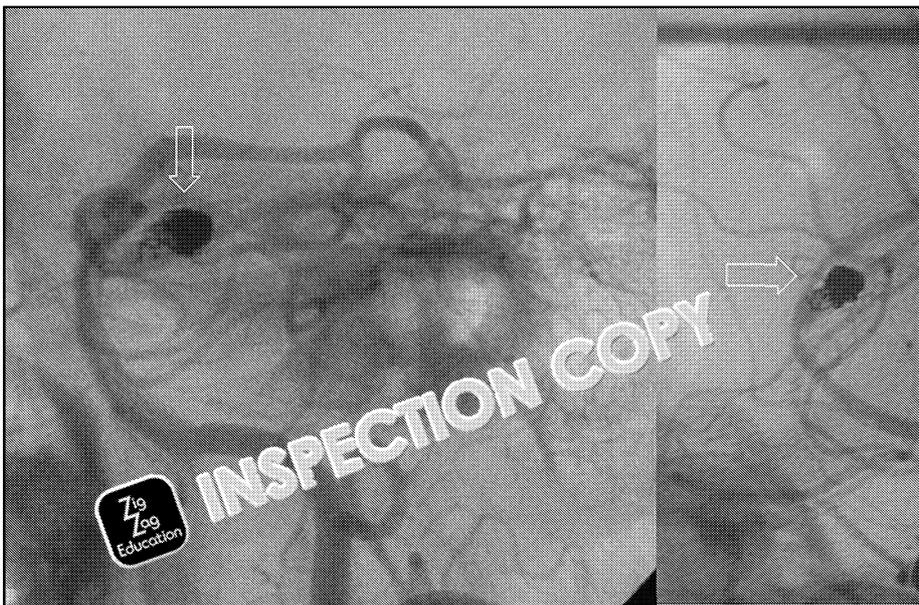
Saccular aneurysm visible in a patient under X-ray, due to the injection of a contrast agent.
